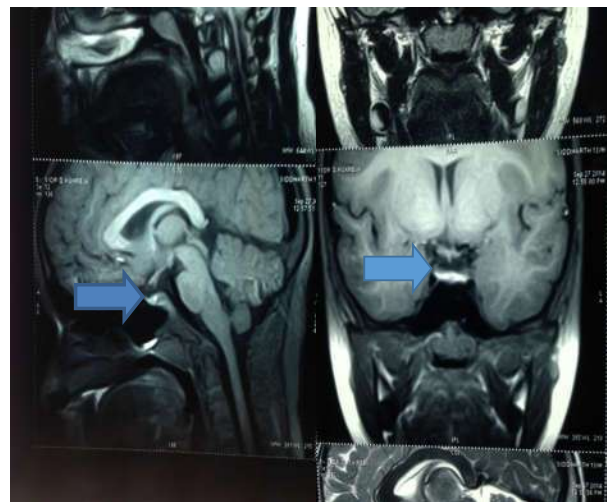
Coronal and sagittal MRI sections showing complete resolution of the pituitary mass in the second MRI
